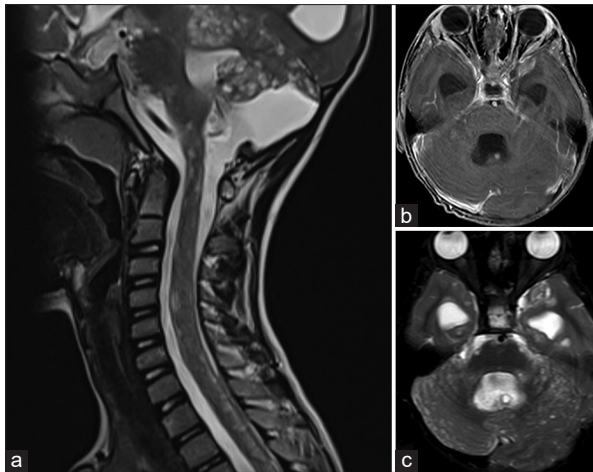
(a and c) T2 fluid-attenuated inversion recovery axial image shows multiple hyperintense cystic lesions in the cerebellum and cervical spine. (b) T1-weighted postcontrast image shows a nodular lesion on the posterior wall of fourth ventricle
